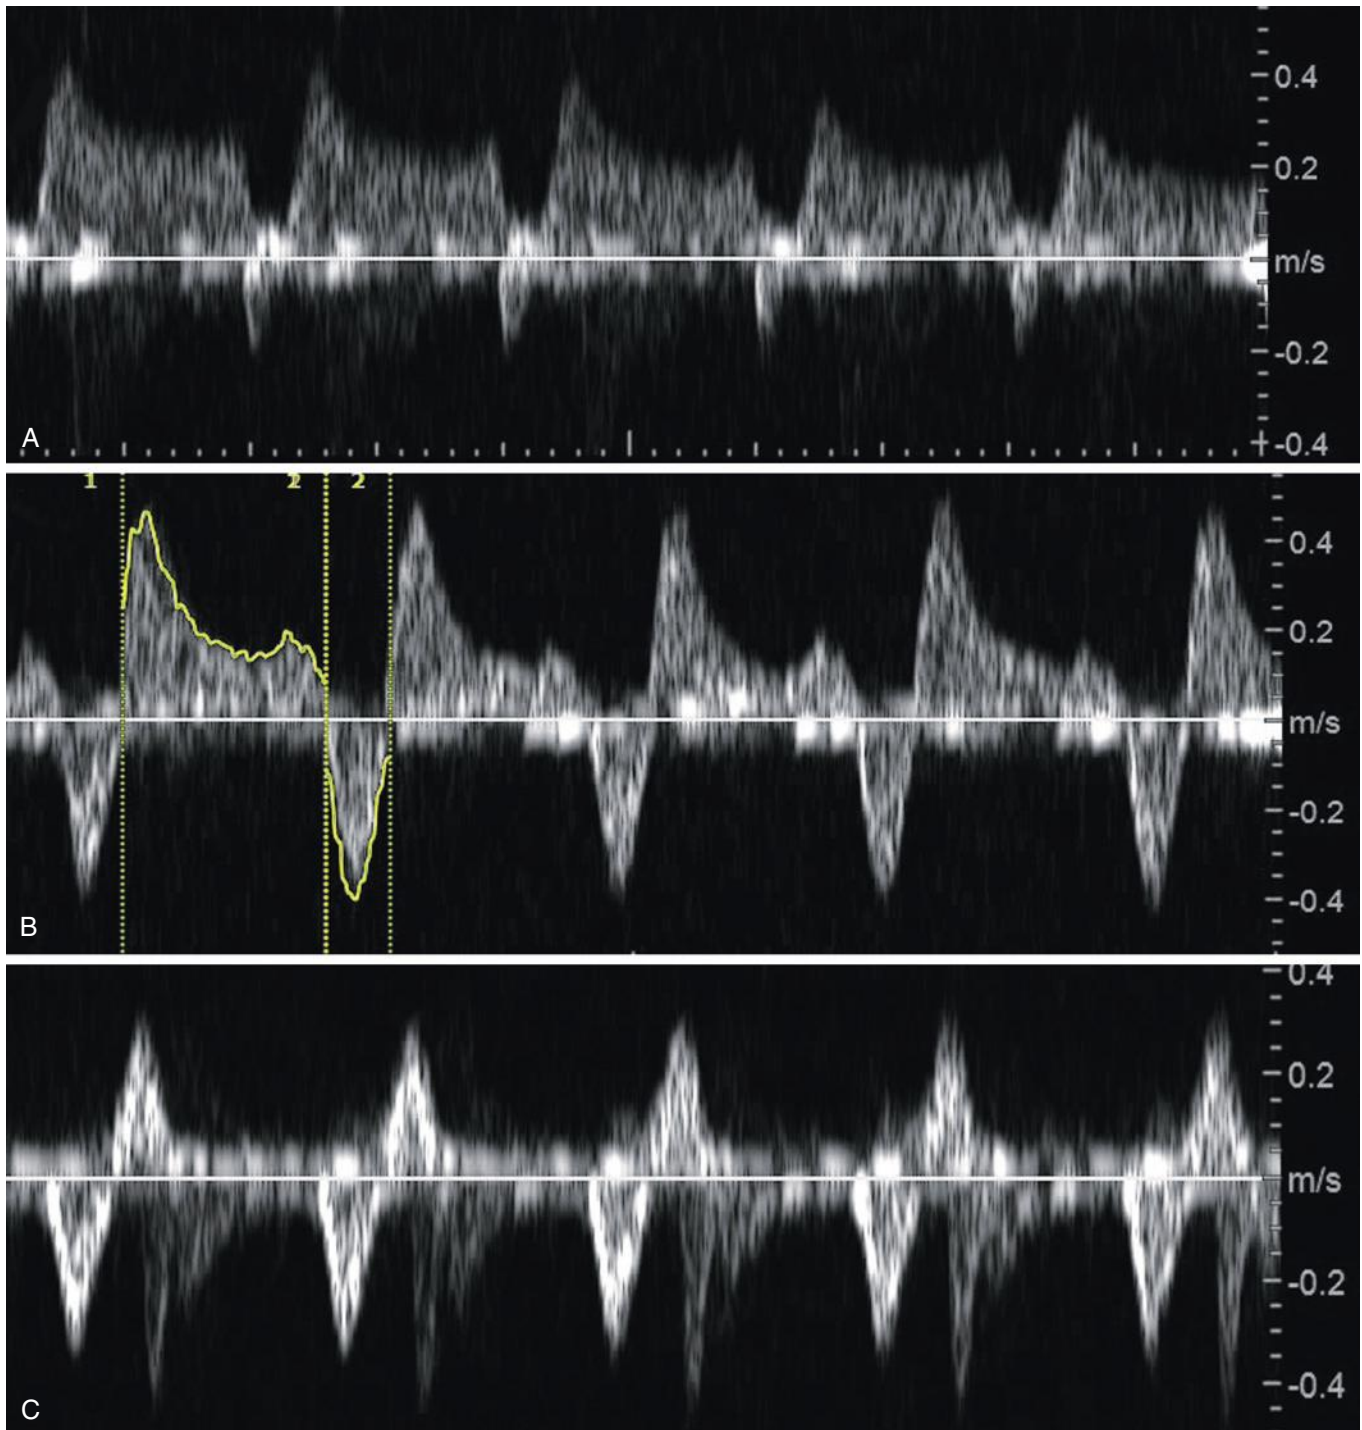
Pulmonary venous Doppler patterns with increasing degrees of atrial level restriction. A, Pulmonary venous Doppler pattern seen with no atrial septal restriction, with a very short period of a-wave reversal. B, Pulmonary venous Doppler pattern seen with mild to moderate obstruction at the atrial septal level. Both a systolic wave and a diastolic wave are seen, but there is more prolonged a-wave reversal. Measurement of the ratio of prograde-retrograde velocity time integral (VTI) is greater than 3 and suggests there will likely not be decompensation at birth. C, Pattern of pulmonary venous flow seen with severe atrial level restriction in HLHS. The VTI of the antegrade flow (below line) is just slightly larger than the VTI of retrograde flow (above line) and suggests acute decompensation postnatally. (From Morris SA, Maskatia SA, Altman CA, Ayres NA: Fetal and perinatal cardiology. In Allen HD, Shaddy RE, Penny DJ, et al [eds]: Moss and Adams' Heart Disease in Infants, Children, and Adolescents Including the Fetus and Young Adult, 9th ed. Philadelphia, Lippincott Wolters Kluwer, 2016, used with permission. Information from Divanović A, Hor K, Cnota J, et al: Prediction and perinatal management of severely restrictive atrial septum in fetuses with critical left heart obstruction: clinical experience using pulmonary venous Doppler analysis. *J Thorac Cardiovasc Surg* 141(4):988-994, 2011.)
